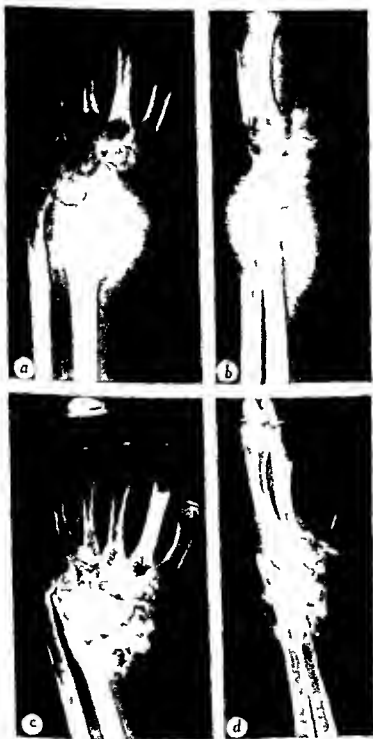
Giant cell tumor of left radius with complete destruction of lower diaphysis and epiphysis and involvement of the wrist. *a* Anteroposterior view. *b* lateral view. *c* and *d* twenty-eight months after operation and after roentgen treatment marked deformity with shortening of radius and destruction of tumor may be noted.
